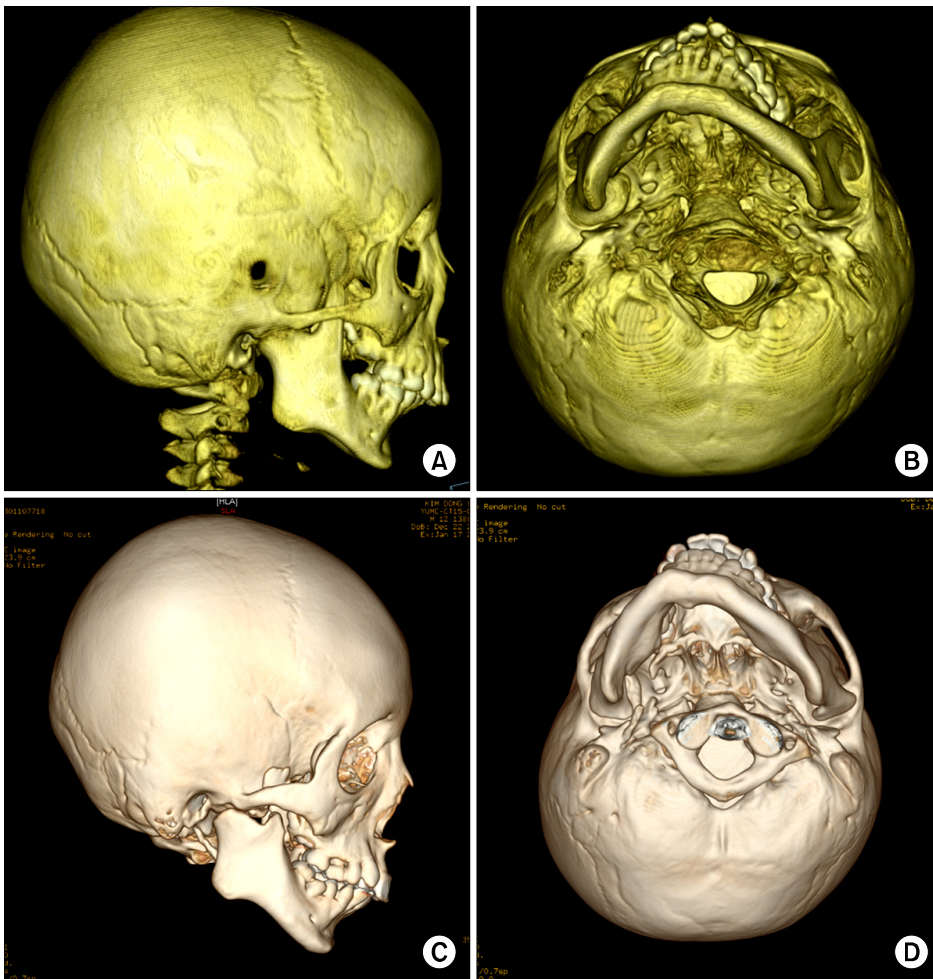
Serial 3-dimensional reconstruction model by computed tomography scan. (A, B) Primary ankylosis at 5 years old. (C, D) Reankylosis after gap arthroplasty at 12 years old.
